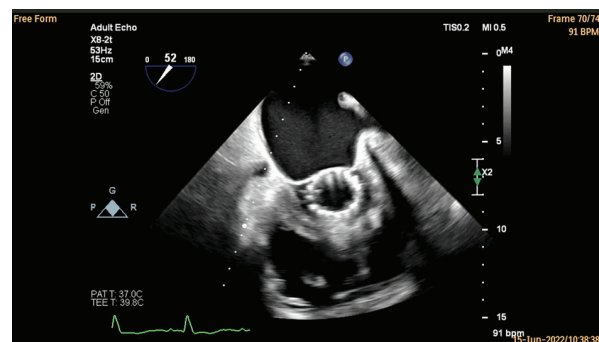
2D transoesophageal echocardiography – Short axis (SAX) aortic bioprosthesis dehiscence
